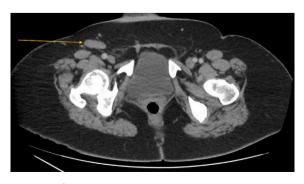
CT of the abdomen shows right inguinal lymphadenopathy which was biopsied (October 2020).
